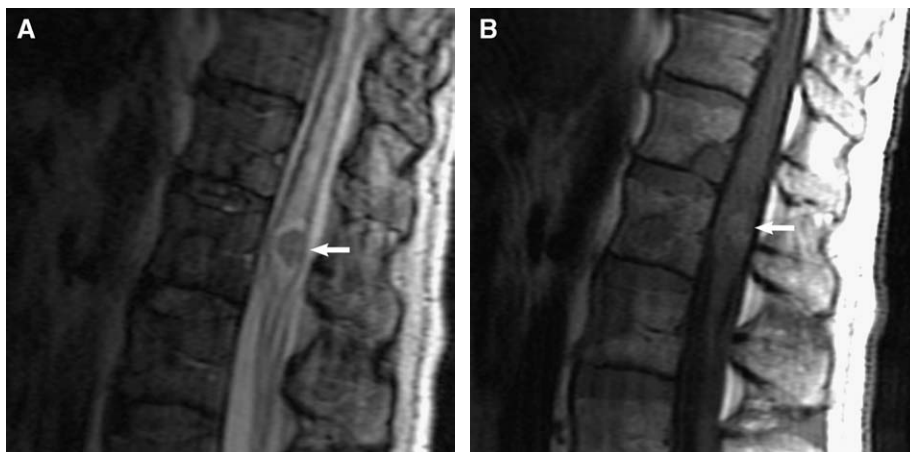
(A) Sagittal T2-weighted image shows an isointense signal intensity rounded intramedullary renal cell carcinoma metastasis in the conus (arrow) with surrounding hyperintense edema. (B) Sagittal contrast-enhanced T1-weighted image confirms a faintly enhancing intramedullary metastasis (arrow).
